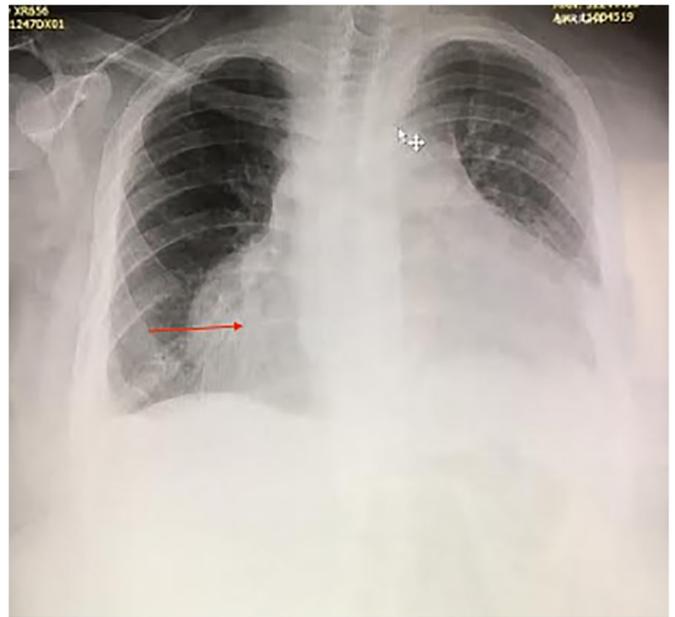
Chest x-ray before pericardiocentesis showing globe-shaped cardiomegaly and clear lungs.
